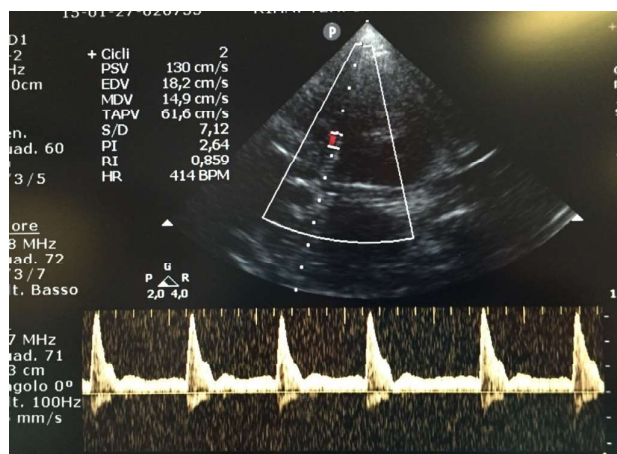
Transcranial Doppler; *Peak systolic velocity (PSV)*: corresponds to the highest point in the spectral waveform during each cardiac cycle. *End-diastolic velocity (EDV)*: corresponds to lowest point in the forward flow waveform. *Mean flow Velocity (MFV)*: Increased MFV indicates stenosis, vasospasm or hyperdynamic flow states. MFV is decreased in hypotension, decreased cerebral blood flow or brain stem death.⁸ *Pulsatility index (PI)*: calculated as the difference between peak systolic and end diastolic flow velocities, divided by the mean flow velocity.⁹ PI does not depend on the angle of insonation and PI > 1.2 indicates high resistance flow.^{10,11} *Resistive index (RI)*: resistance to flow distal to the insonated area of the vessel. RI is calculated as the difference between PSV and EDV, divided by PSV. Normal value is less than 0.75.¹¹
